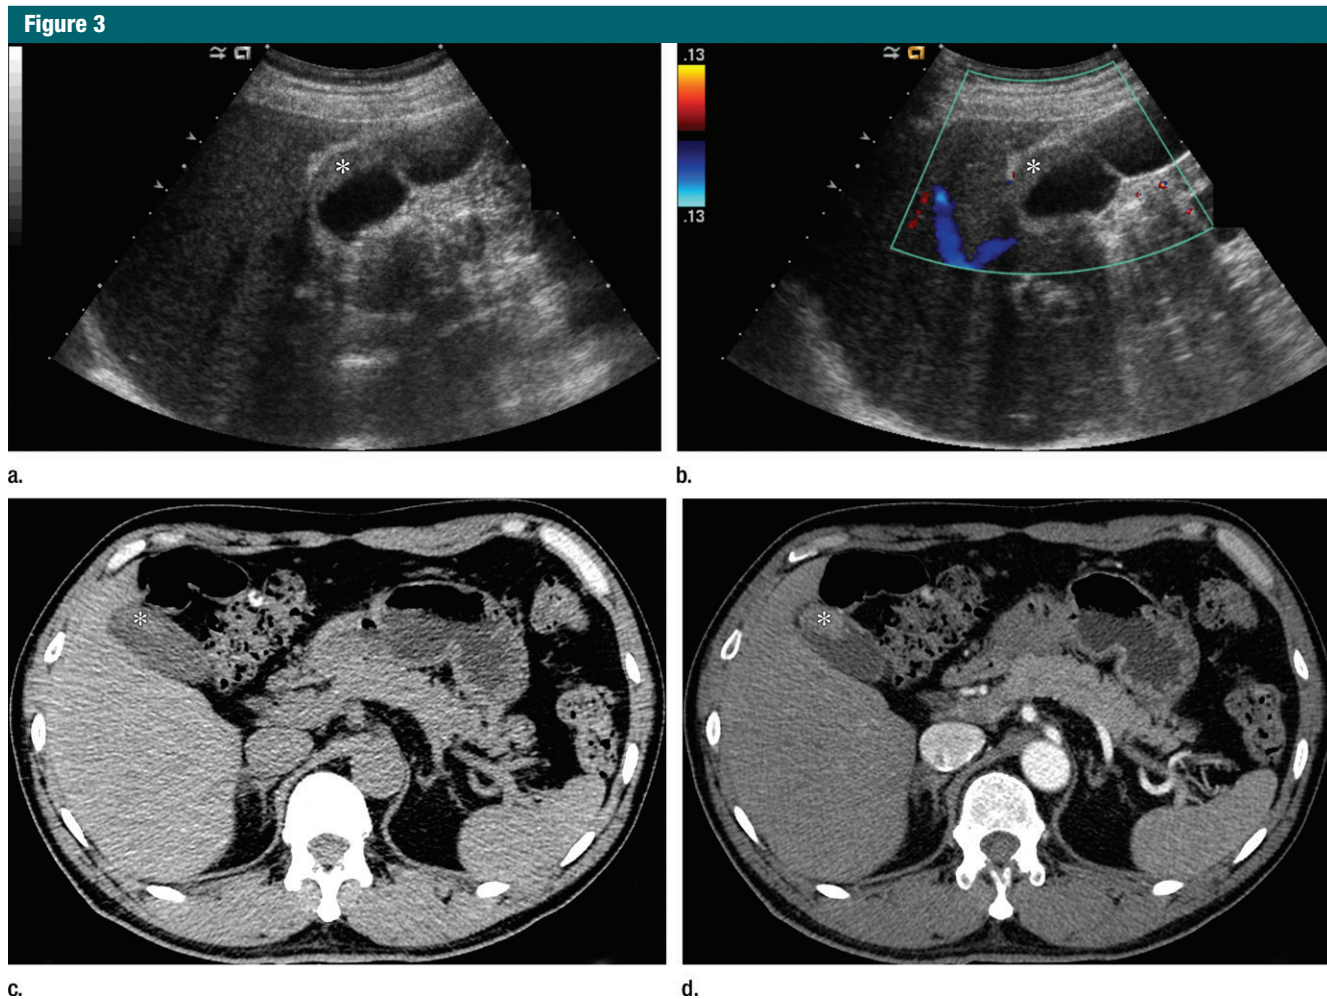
Images in a 63-year-old woman with operable malignant tumefactive sludge. (a) On B-mode US image, a 2.8-cm echogenic mass without movability is located in body to fundus of gallbladder (*). (b) On color Doppler US image, lesion (*) does not have internal vascularity. (c) Axial unenhanced CT image shows iso- to hypointense lesion in gallbladder (*) compared with adjacent liver. (d) On arterial phase axial CT image, lesion is highly enhancing (*) and is confirmed to be gallbladder cancer at radical cholecystectomy.
